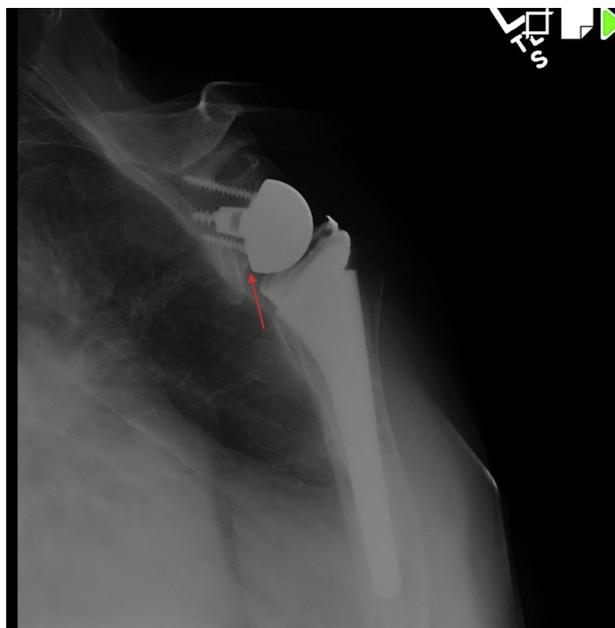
Postoperative radiograph of a 78-year-old patient with a 135° prosthesis demonstrates grade 1 scapular notching (*red arrow*).
